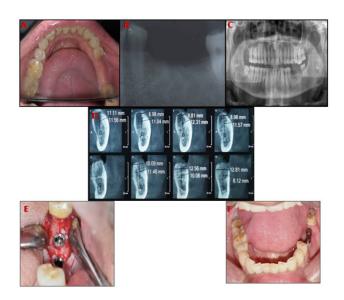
Mandibular left posterior region. (A) Pre-operative clinical. (B) Pre-operative IOPA. (C) Pre-operative OPG. (D) Pre-operative CBCT. (E) Implant placed. (F) Implants with abutment.
